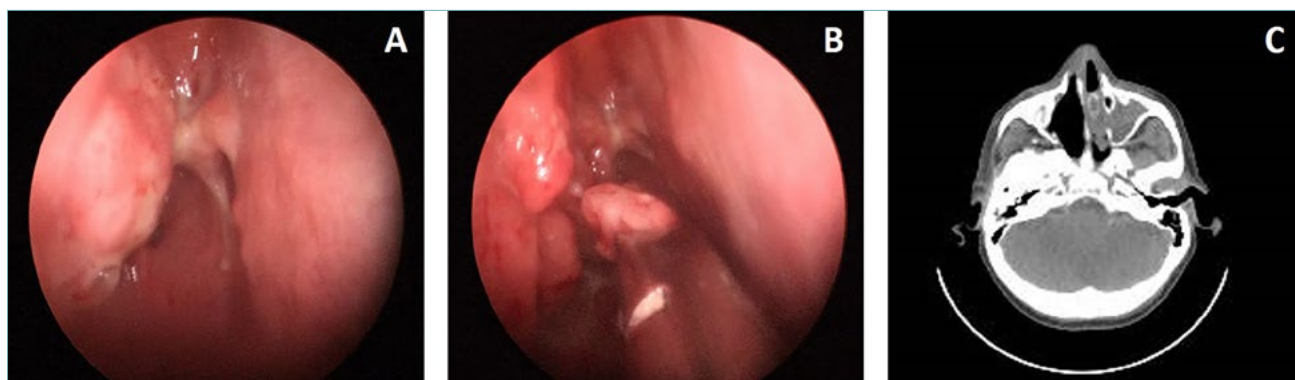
(A) Flexible fiber optic endoscopy shows the polypoidal mass in the right nasal cavity. (B) Biopsy performed during endoscopic sinus surgery (ESS). (C) Pre-surgical maxillo-facial CT shows a mass that completely obliterates the right nasal cavity, the ipsilateral maxillary sinus, and expands posteriorly toward the right nasopharynx.
